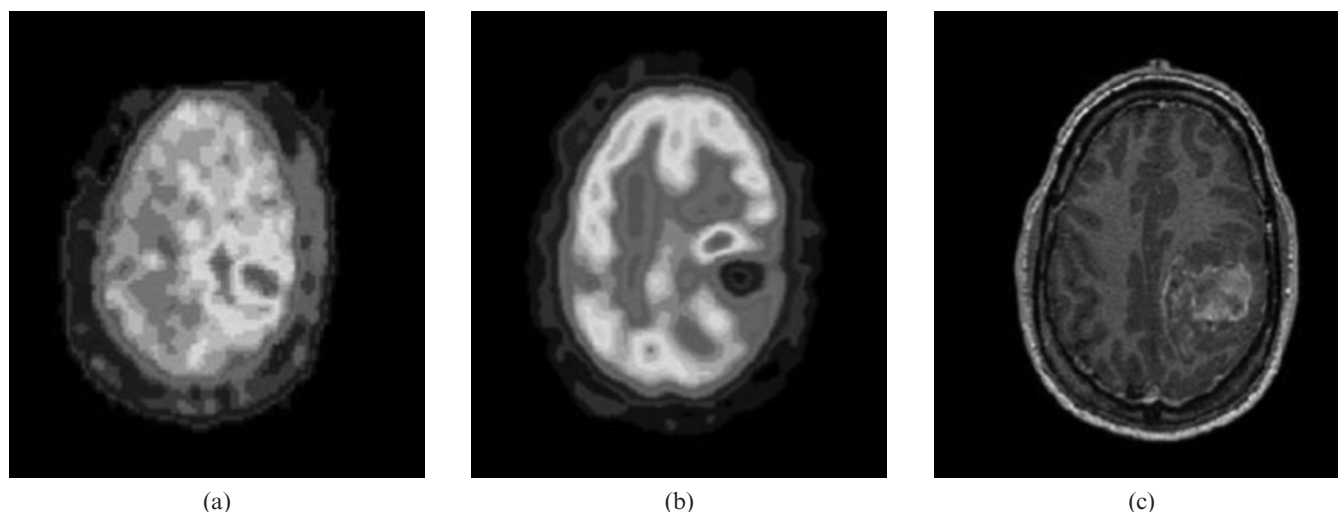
High-grade glioma (grade IV). (a) ^{18}F -labelled fluoro-misonidazole (^{18}F -MISO) positron emission tomography (PET). (b) ^{18}F -fluorodeoxyglucose (FDG) PET. (c) MRI. ^{18}F -FDG and ^{18}F -MISO uptake is evident in the left posterior parietal glioma, with uptake absent in the central necrotic area, although different patterns of maximal glucose metabolic rate and hypoxia are evident. Reproduced with permission from [128].
